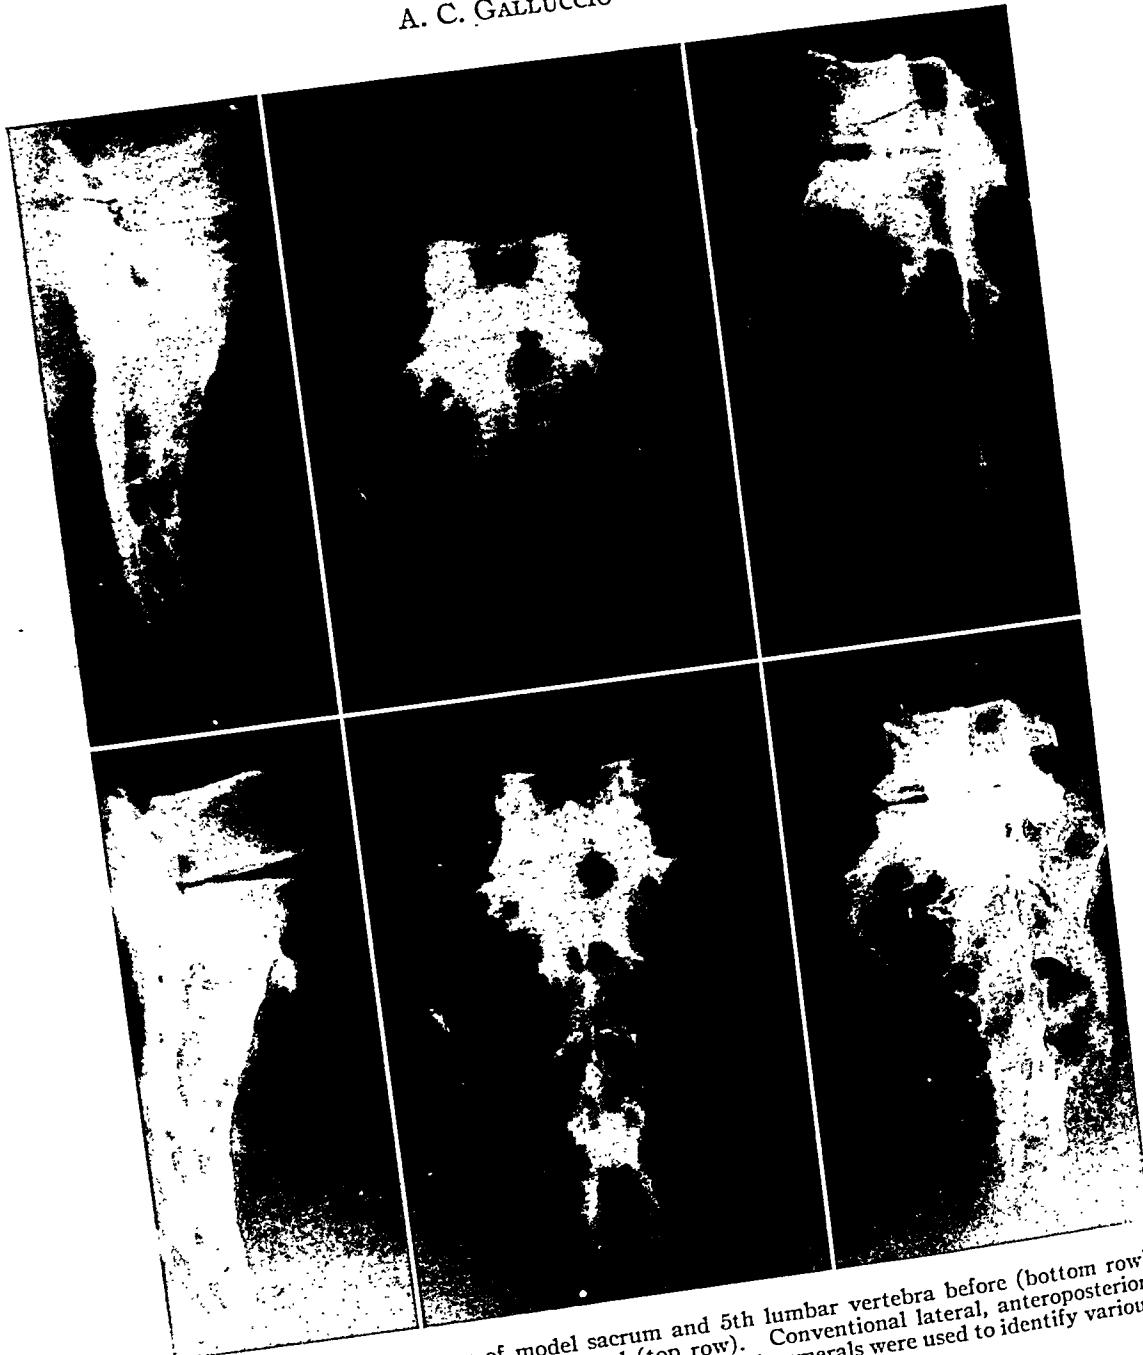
Roentgenograms of model sacrum and 5th lumbar vertebra before (bottom row) and after defect was artificially produced (top row). Conventional lateral, anteroposterior, and oblique views shown in the order mentioned. Lead numerals were used to identify various structures.
